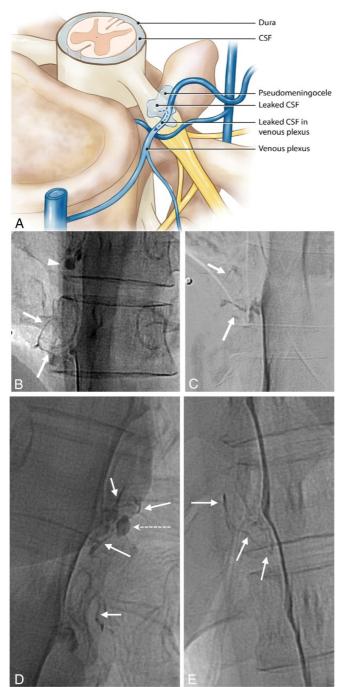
Image from: Spontaneous Intracranial Hypotension: A Systematic Imaging Approach for CSF Leak Localization and Management Based on MRI and Digital Subtraction Myelography [19].
